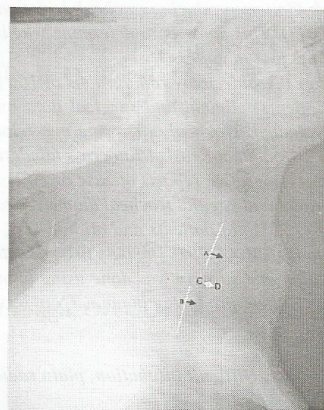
Lateral neck radiograph demonstrating tracheal narrowing in goiter and the assessment for both length (distance A-B) and width (distance C-D) of narrowing.
